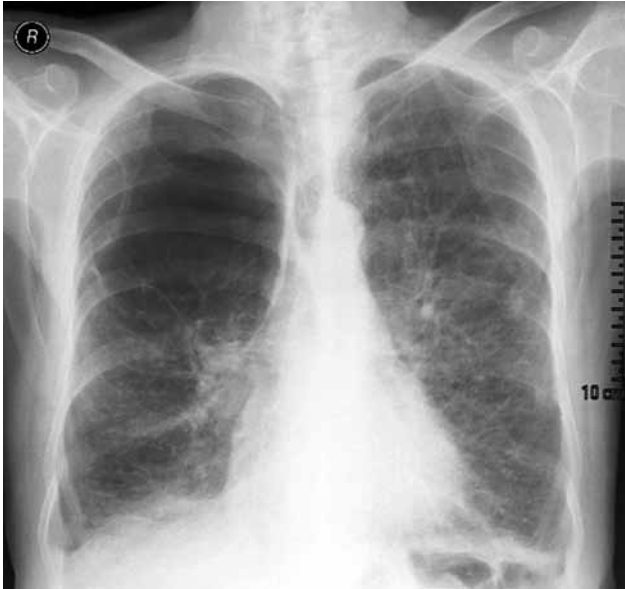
Preoperative chest X-ray revealing a giant bulla in the right hemithorax.
